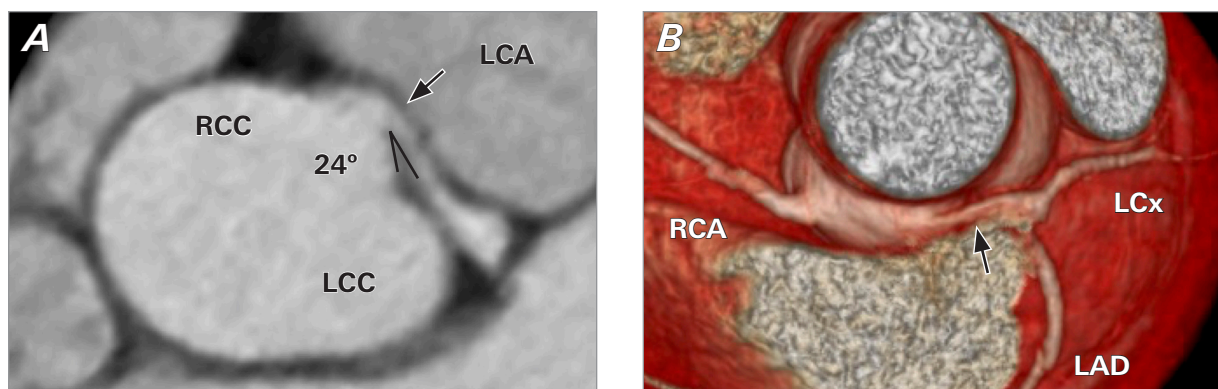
Findings of coronary computed tomography angiography in the patient before the operation. A) The origin of the LCA was the right sinus of Valsalva (arrow) and the takeoff angle was acute (24°), and B) it showed a slit-like orifice, as indicated by the arrow.
